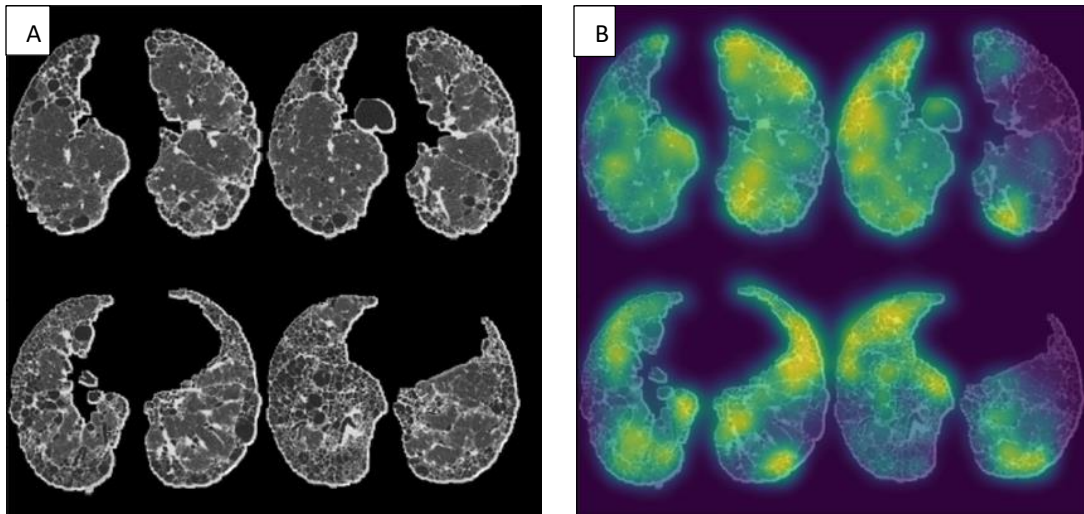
Systematic Objective Fibrotic lung disease analysis Algorithm. A) Four slice HRCT montage of segmented lung slices depicted peripheral honeycombing consistent with a UIP pattern. SOFIA (Systematic Objective Fibrotic lung disease analysis Algorithm) scores for this case were UIP: 0.9963, Probable UIP: 0.0036, Indeterminate: 0.0001, and Alternative diagnosis: 0.000. B) Saliency map for Figure A highlighting regions within the montage that were most influential algorithmic decision-making.
